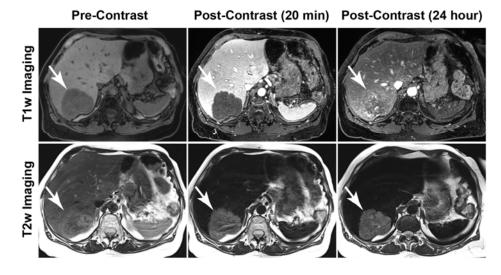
Pre-, 20 min post-, and 24 hour post-ferumoxytol T1-and T2-weighted imaging. The white arrows indicate the liver metastasis.
